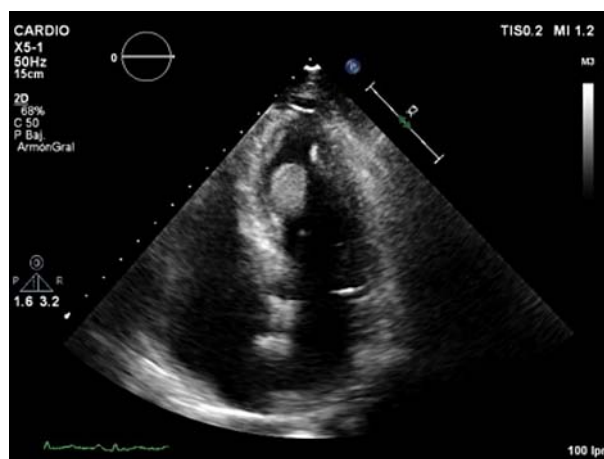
Apical four-chamber echocardiographic view. Left ventricular mass attached to inferior interventricular septum.
